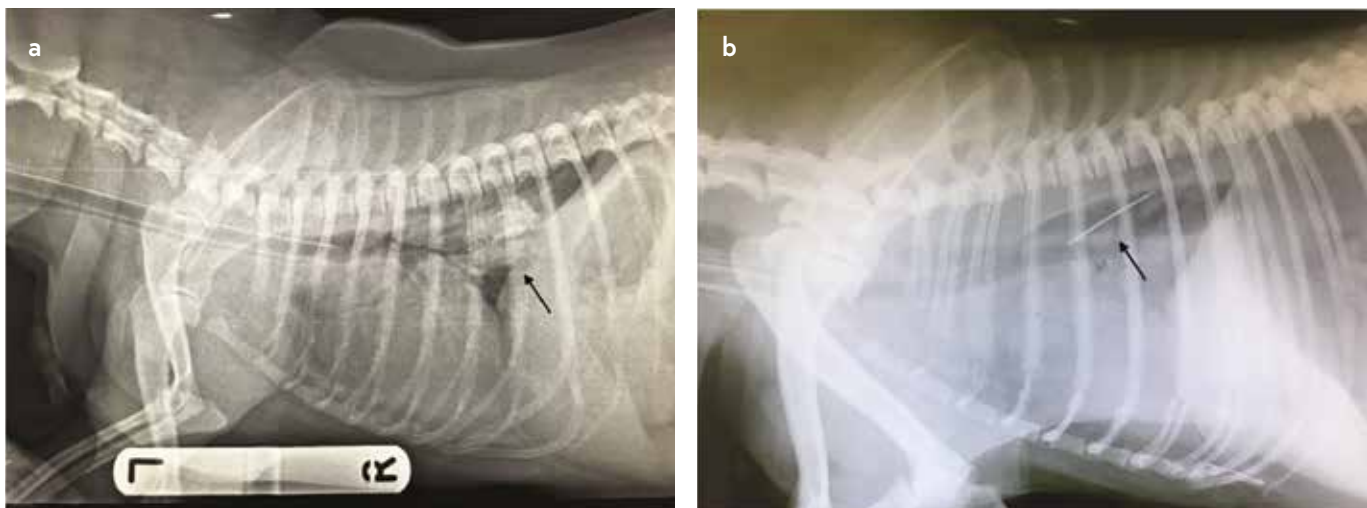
Lateral thoracic radiographs of two different esophageal foreign bodies, (a) pork bone and (b) needle, lodged in the caudal thoracic esophagus (black arrow).
